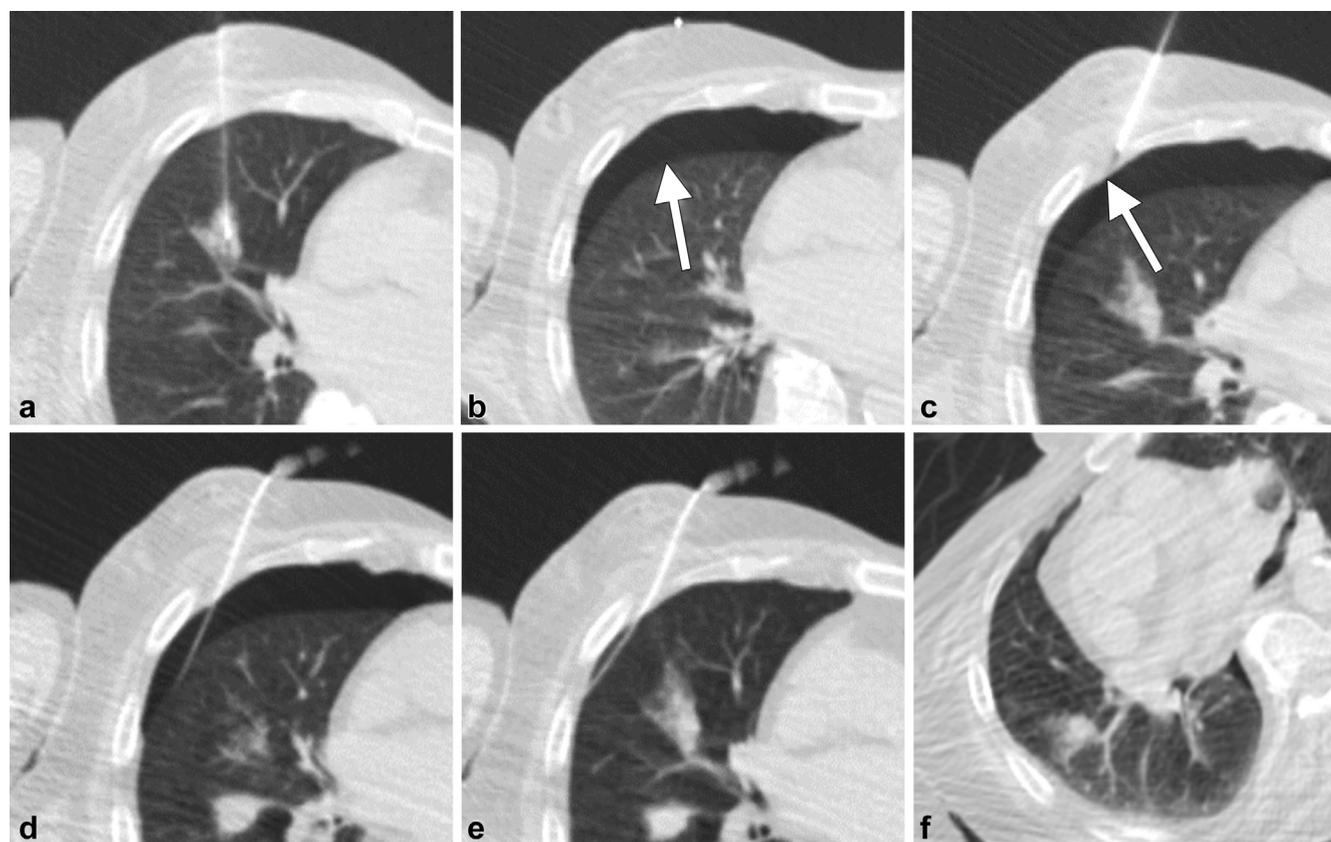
Pleural blood patch technique in a 70-year-old man undergoing biopsy of a pulmonary nodule in the right middle lobe. (a) Guide needle placed into the targeted mass. (b) A growing pneumothorax is detected after biopsy (white arrow). (c) Additional local anesthesia (1% lidocaine with epinephrine [1:100,000]) placed to the pleural surface. A skin puncture near the biopsy site is used for blood patching, and additional anesthesia is not always necessary. Note the slight intercostal tissue convexity (white arrow), which denotes adequate local anesthesia. (d) A straight 5-F multiside hole catheter (Yueh Centesis Catheter) is placed into the pleural space tangential to the lung surface to avoid injuring the lung during reinflation. (e) The pneumothorax is evacuated with wall suction, and 7–90 mL of autologous blood injected into the pleural space. (f) The catheter is removed, and the patient is immediately placed into the right lateral decubitus position for 15 minutes. Repeat scanning is performed before the patient is moved to the recovery area. If the pleural blood patch had failed with the reaccumulation of the pneumothorax, a conventional chest tube would have been placed in the second or third intercostal space midclavicular line, followed by hospital admission. The chest X-ray shows no reaccumulation of the pneumothorax 3 hours after biopsy (not shown). The patient was discharged the same day without sequela.
